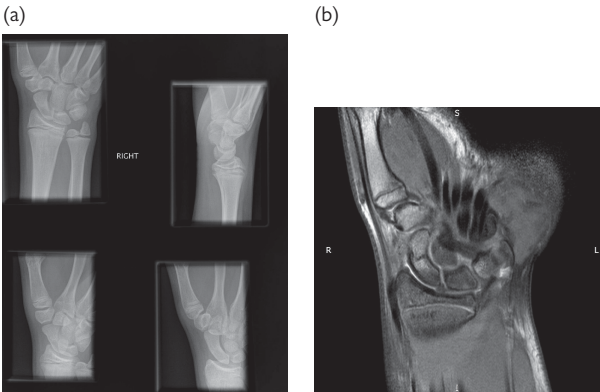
Scaphoid fracture in 15y old seen at 2 weeks on (b) MRI, but not (a) X-ray.
